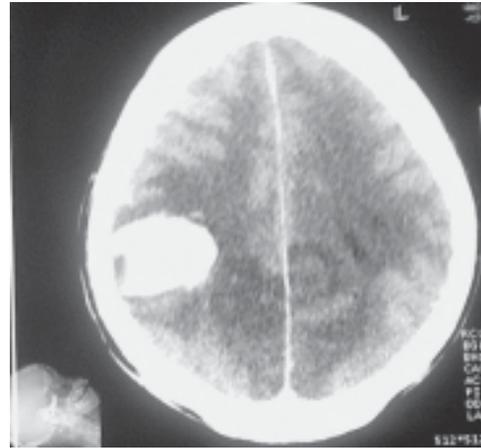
Plain CT scan showing right parietal ICH
